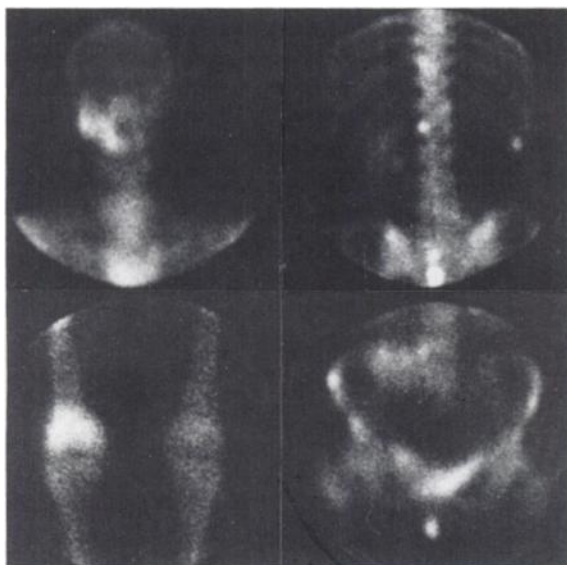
Bone scintigrams after injection of $^{99\text{m}}\text{Tc}$ -DPD shows bone metastases in the head, spine, pelvis and knee.
